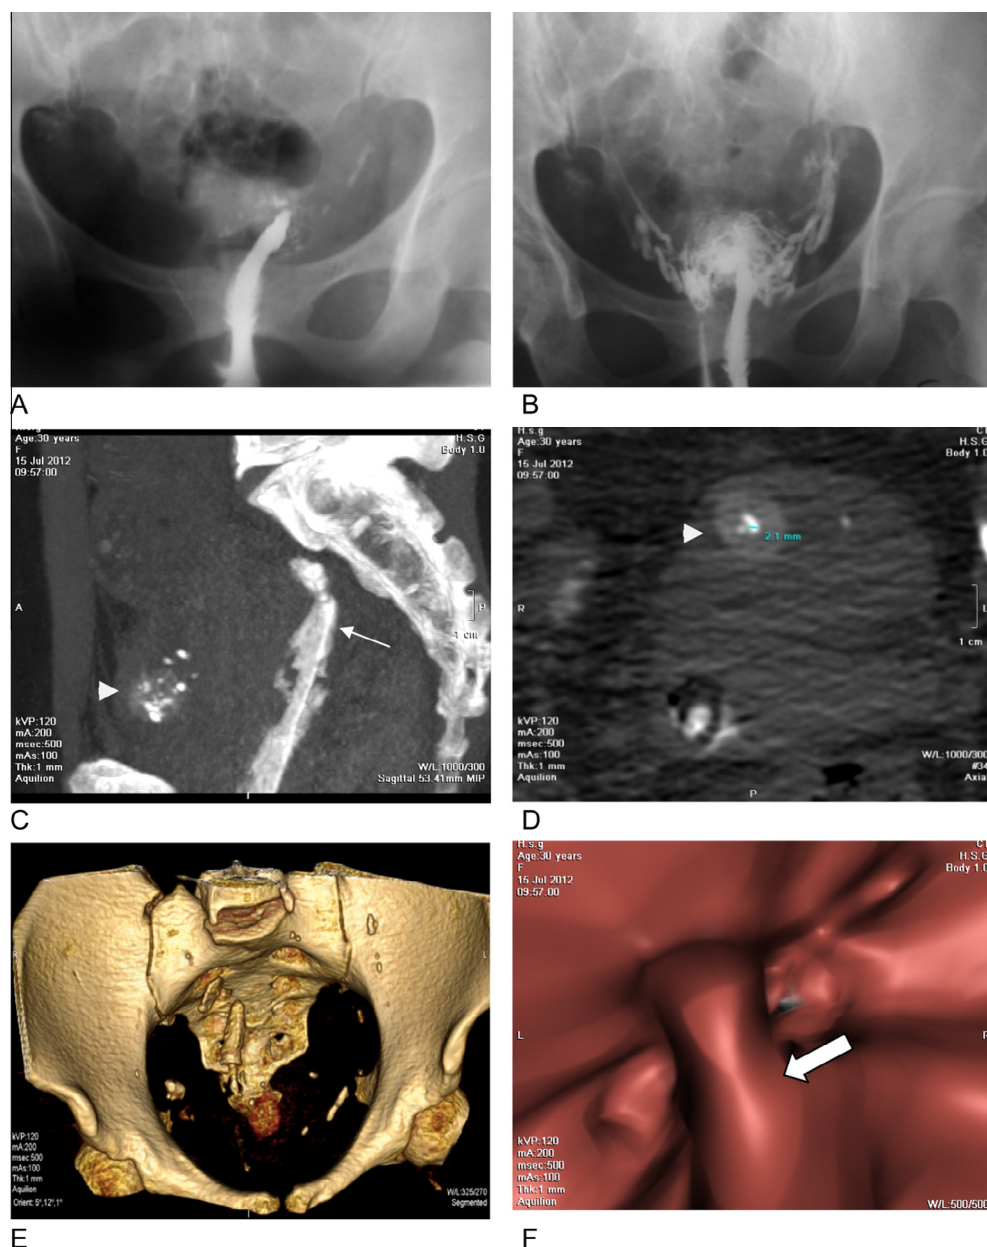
Asherman's syndrome. (A and B) The X-ray HSG revealed opacification of the cervical canal with non opacified uterine cavity and extensive intravasation of the contrast media. The MDCT VHSG revealed opacification of the cervical canal (long arrow) with extensive intrauterine adhesion and synechiae (wide arrow) resulting in very small uterine cavity (2 mm) which was outlined by enhancing endometrial lining (arrow head). Intravasation into the uterine and iliac arteries also has occurred, (C and D) Maximum intensity projections. (E) Volume rendering reconstruction. (F) Virtual endoscopy view.
